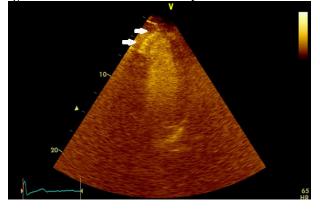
Echocardiographic assessment after administration of the myocardial contrast agent (Sonovue) four chamber view- showing significant improvement of the segmental wall motion in the territory of LAD
